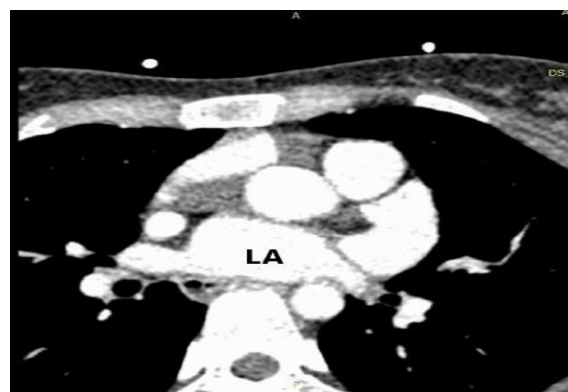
Left atrium (LA) seen in computed tomography (CT) angiography without unroofed coronary sinus (CS)
